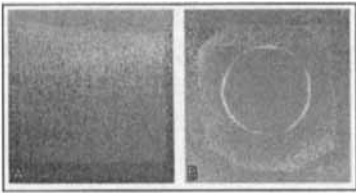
X-ray of sample where A shows sample before testing. B shows sample after 4x10⁶ cycles.
